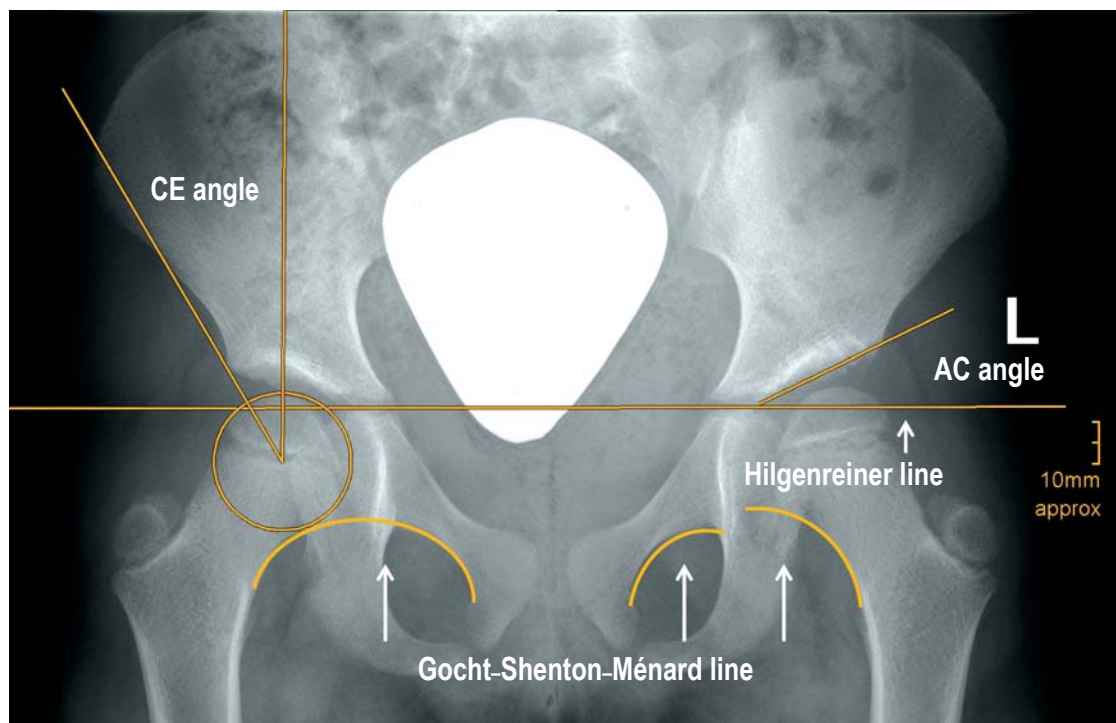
Measurements on a pelvic radiograph, showing the reference lines and angular measurements (AC and CE) in an assessment of hip dysplasia/displacement
